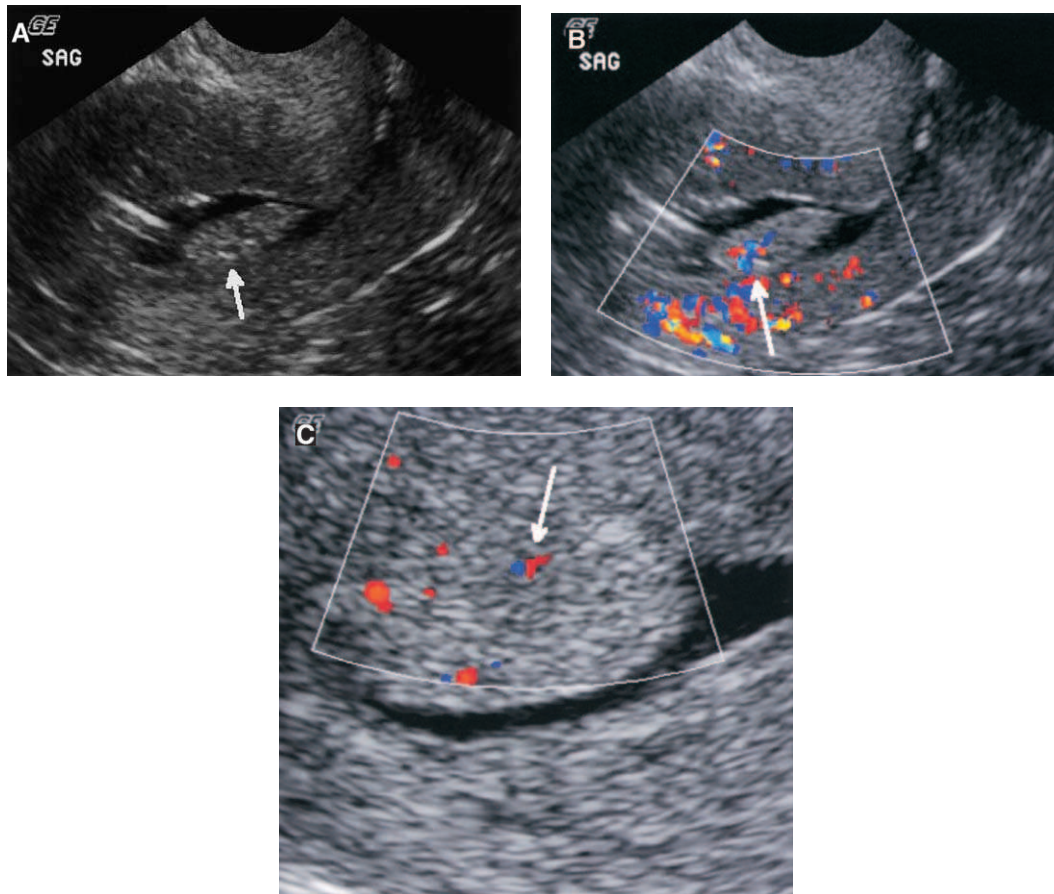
(A, B) Doppler interrogation of the stalk of the polyp arising from the posterior endometrial surface in this 51-year-old woman with postmenopausal bleeding (PMB) demonstrates the characteristic prominent color Doppler flow (arrows). (C) Doppler interrogation of the base of a submucosal fibroid in a 56-year-old woman with PMB demonstrates a similar vascular pedicle (arrow). This feature is most often seen in endometrial polyps but is nonspecific and is occasionally observed in other endometrial and subendometrial pathologies.
